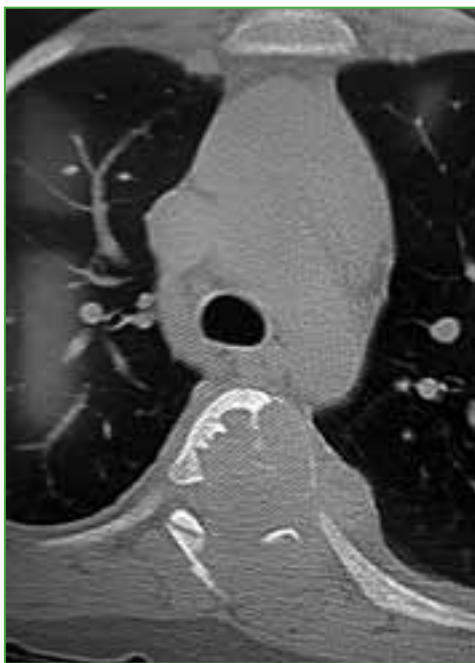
Axial computed tomography of the thoracic spine. Multiple fluid–fluid levels are identified within the cystic lesion.
